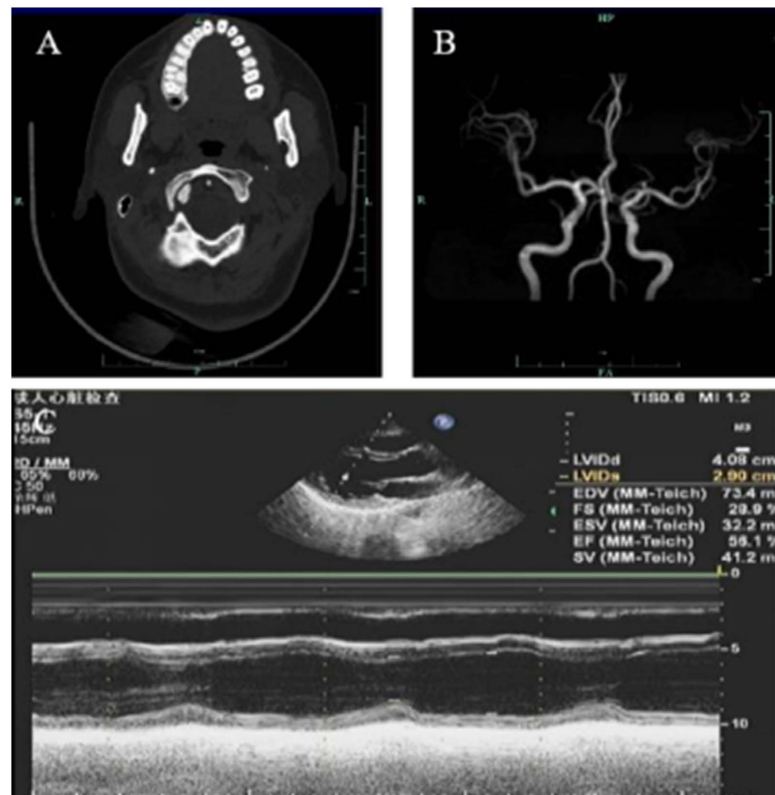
CT, MRI and color Doppler images of the patients. A. CT plain scan of head; B MRA cerebrovascular imaging; C color Doppler echocardiography. No abnormality was found in CT, MRI and color Doppler echocardiography.
